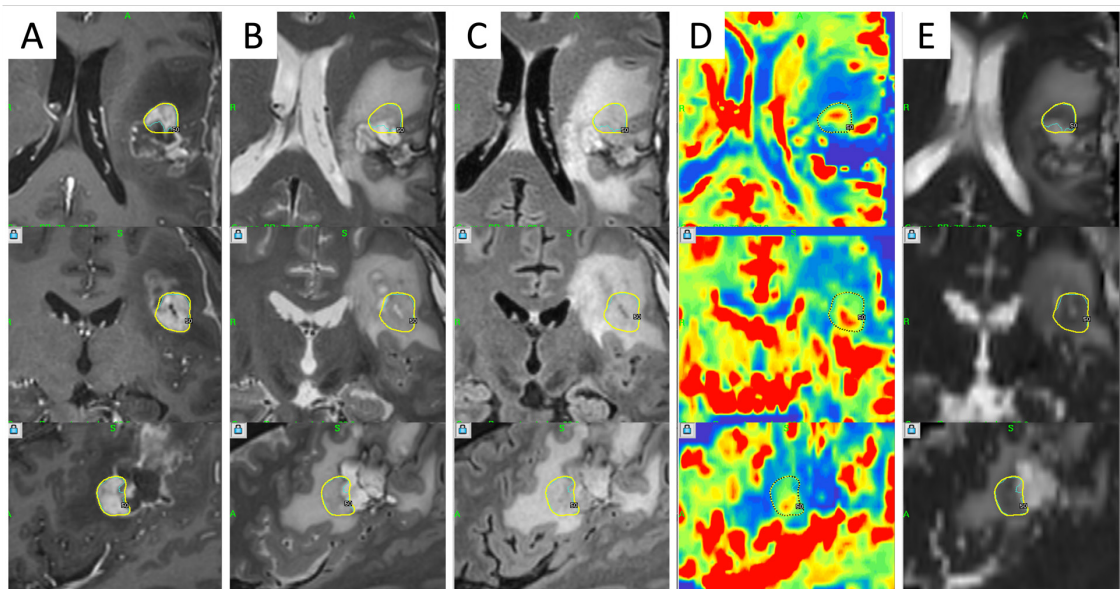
Integration of advanced MRI sequences in a Gamma Knife radiosurgical planning for a recurrent WHO grade III astrocytoma
